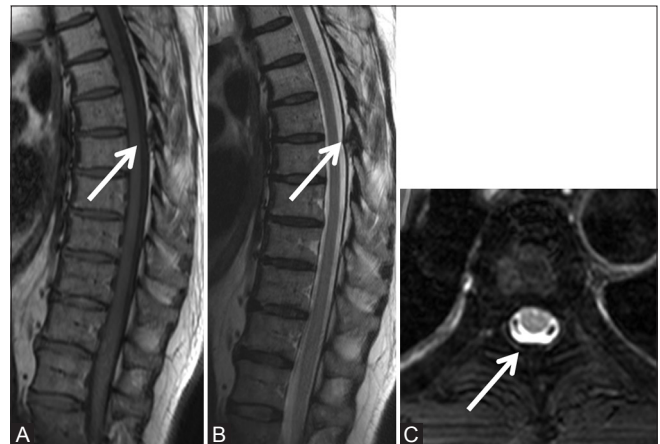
(A-C): Degenerative: Hypertrophied ligamentum flavum: Sagittal T1-weighted (A), T2-weighted (B), and axial T2 fat saturated (C) images of thoracic spine in a 62-year-old male with a known carcinoma of the lung with backache, showing focal hypertrophy of ligamentum flavum (arrow) at T4-5 level effacing the posterior epidural space. No abnormal vertebral signal or soft tissue noted on axial images
